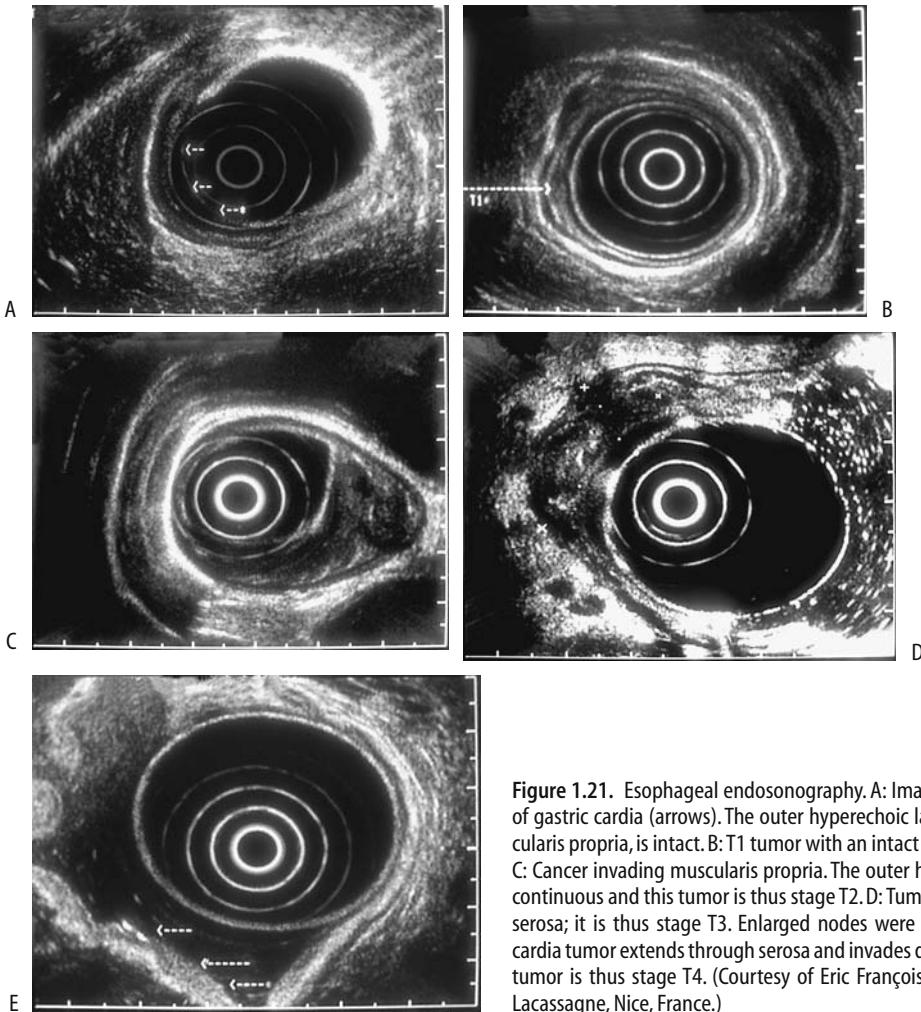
Esophageal endosonography. A: Image of superficial cancer of gastric cardia (arrows). The outer hyperechoic layer, representing muscularis propria, is intact. B: T1 tumor with an intact outer hypoechoic layer. C: Cancer invading muscularis propria. The outer hyperechoic layer is discontinuous and this tumor is thus stage T2. D: Tumor invading beyond the serosa; it is thus stage T3. Enlarged nodes were also present. E: Gastric cardia tumor extends through serosa and invades diaphragm (arrows). The tumor is thus stage T4. (Courtesy of Eric François, M.D., Centre Antoine-Lacassagne, Nice, France.)
